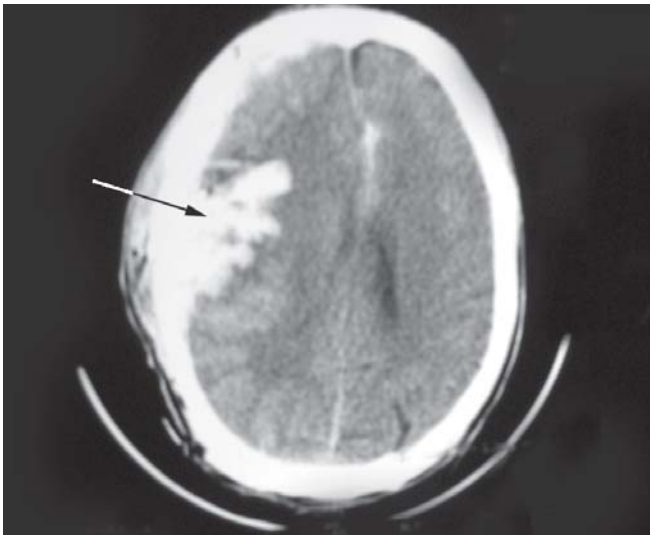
CT head showing intracerebral hemorrhage
